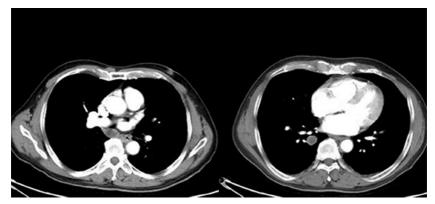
CT on 2/4/2015: upper and middle
